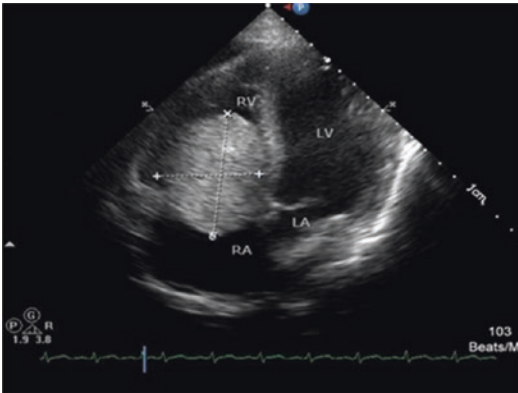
Echocardiographic appearance of a right ventricle myxoma
